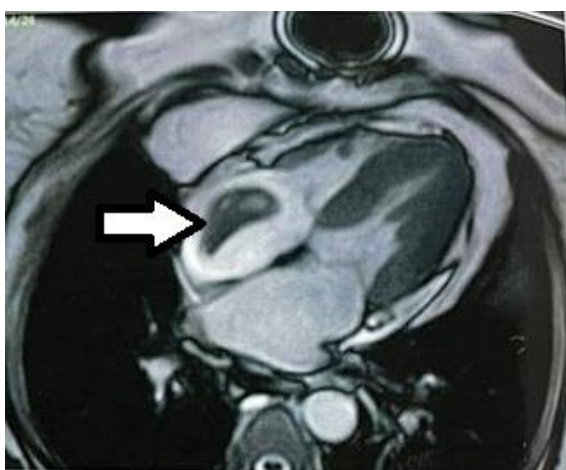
Cardiac MRI shows an intraluminal thrombus within the SVC, extending from the RA-SVC junction, of size: 42*20 mm.
